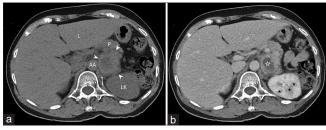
The transverse views of nonenhanced (a) and contrast-enhanced (b) computed tomography scan confirm the location of the mass (arrowheads) behind the pancreas (p) and left lateral to the abdominal aorta (AA). The mass is composed of an enhancing solid part peripherally and a nonenhancing cystic part centrally (open star). The mass is very close to the left adrenal gland (arrow) and the fat plane between them is not clearly visible. Note that some areas with poor contrast enhancement in the left renal parenchyma (stars) are consistent with acute pyelonephritis, which is not obvious on the sonogram. L, liver; LK, left kidney
